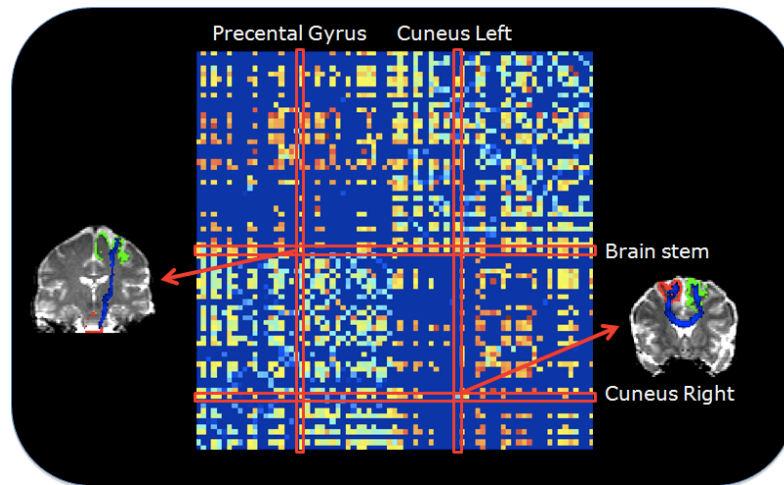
Whole-brain connectivity matrix for a subject. It has been extracted from a subject based on DWI in 64 directions and Robinson *et al.* methodology in estimating connectivity strength [Robinson *et al.*, 2010]. This shows direct structural connections between each pair of cortical regions. The colormap reflects the strength of each connection with deep blue representing the absence of a structural connection between two regions. Regions of interest (ROIs) are plotted by cerebral hemispheres, with right-hemispheric ROIs in the lower left quadrant, left-hemispheric ROIs in the top right quadrant, and inter-hemispheric connections in the upper left and lower right quadrants.
